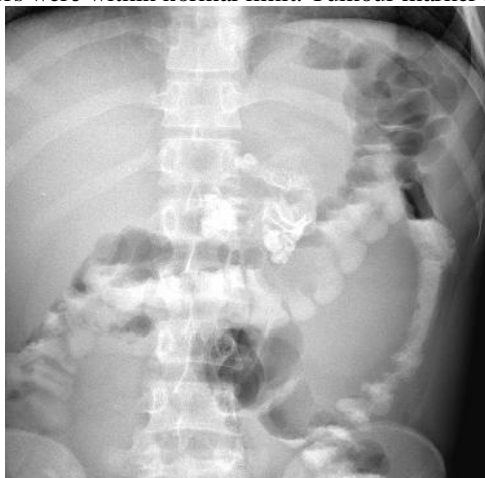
X-ray Abdomen shows calcification with dilated bowel the presence of calcification.
